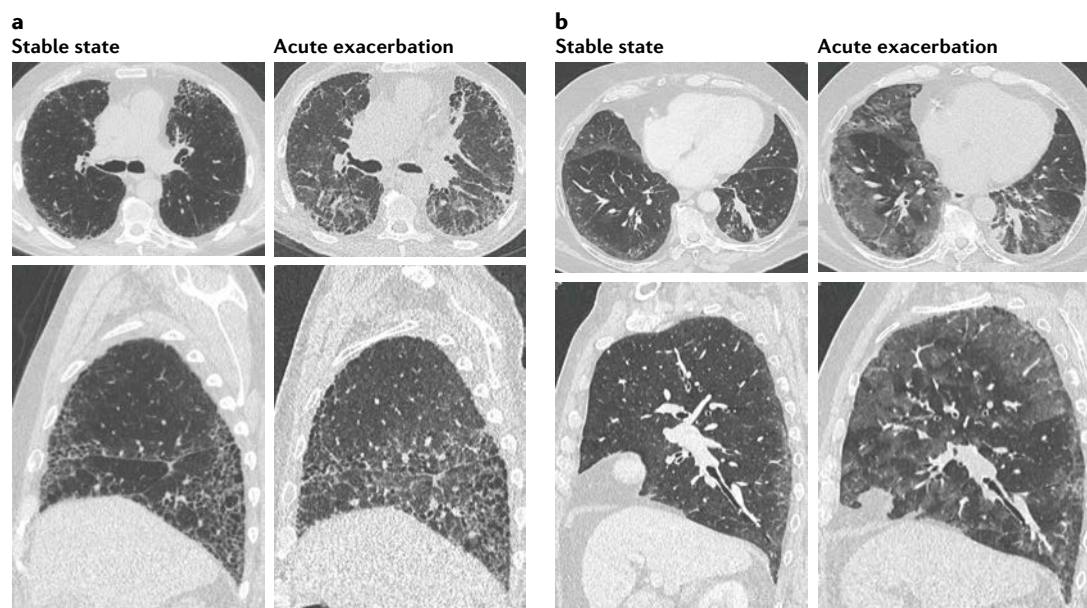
High-resolution chest CT in stable state and acute exacerbation of interstitial lung disease in rheumatic disease. a,b | Interstitial lung disease (ILD) with usual interstitial pneumonia (UIP) pattern in a 59-year-old patient with rheumatoid arthritis (RA). a | Baseline high-resolution CT (HRCT) in the stable state shows a typical UIP pattern with subpleural reticulation layered with propeller-blade distribution across lung zones, traction bronchiolectasis–bronchiectasis and further signs of distortion with volume loss. b | After 14 months, the patient experienced acute shortness of breath leading to respiratory failure, showing substantial morphological changes on HRCT: ground-glass opacities with extensive patchy distribution, increase in subpleural reticulation and of severity in traction bronchiectasis, and signs of volume loss. c,d | ILD with non-specific interstitial pneumonia (NSIP) pattern in a 53-year-old patient with systemic sclerosis. c | Baseline HRCT in the stable state shows NSIP pattern with ground-glass opacities with homogeneous distribution and sparing of subpleural parenchyma. d | After 3 months, the patient experienced acute shortness of breath leading to respiratory failure, showing substantial morphological changes on HRCT: increased extent of ground-glass opacities with diffuse involvement of all the lung parenchyma, with some areas of patchy sparing, without apparent signs of substantial volume loss. Images courtesy of Nicola Sverzellati and Mario Silva.
